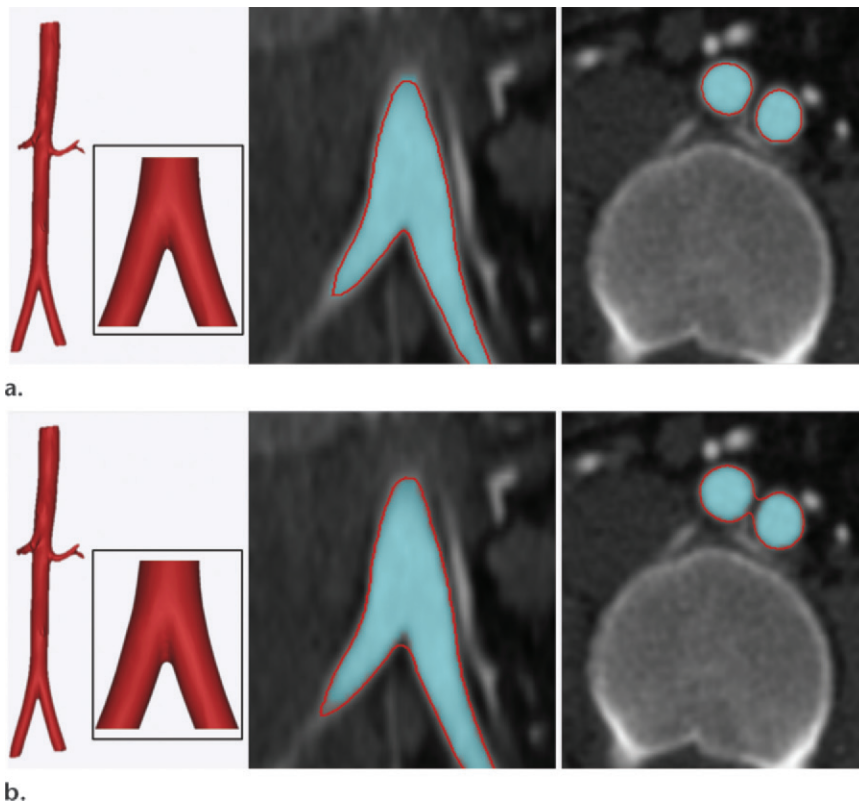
Postprocessing of contrast-enhanced CT images of the abdominal aorta. (a) On coronal (middle) and axial (right) CT images, the aorta is segmented by using thresholding (turquoise in a and b), and an enclosing STL surface (3D rendition on left and red outlines in a and b) is generated. (b) On the coronal (middle) and axial (right) CT images, subsequent refinement of the STL file by using standard smoothing and wrapping operations may no longer correctly describe the anatomy.
